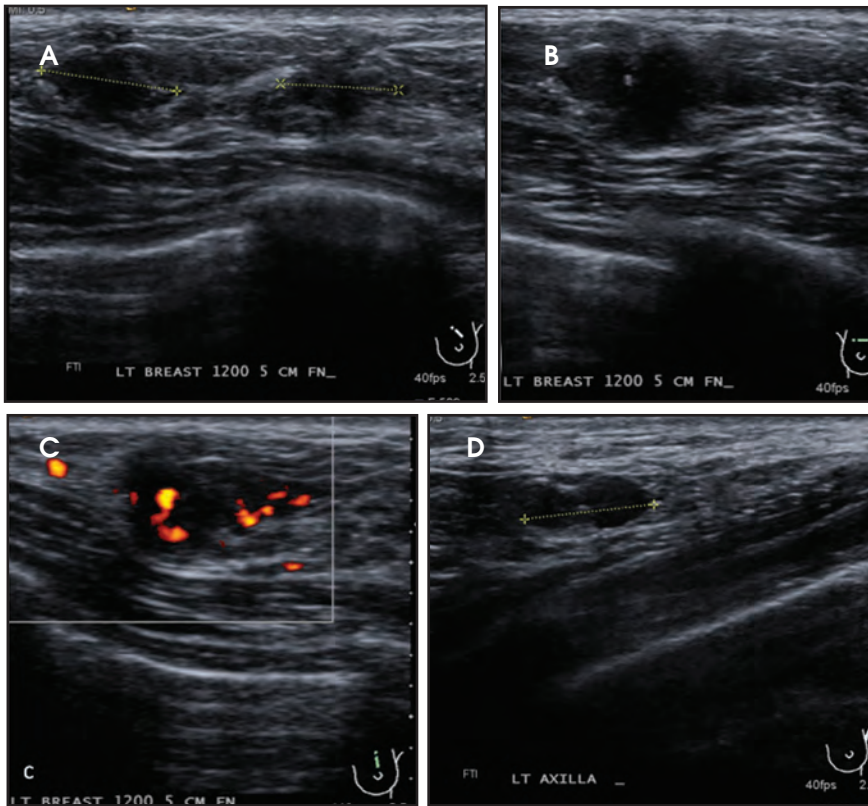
Left breast and left axillary ultrasound. (A) Two contiguous similarly hypoechoic irregular solid masses are noted at 12 o'clock (calipers). Each mass is subcentimeter, measuring 9mm and 8mm. (B) The dominant 9-mm mass corresponds to the highly suspicious mass seen on MRI (Figures 7A - C) and (C) demonstrates significant vascularity. The second similar smaller 8-mm mass corresponds to confluent enhancing foci on MRI. (D) Ultrasound of the left axilla demonstrates the 9-mm lymph node with thickened cortex noted on MRI and is categorized as suspicious. Overall, the BIRADS assessment is confirmed as category 5, highly suspicious for malignancy. Recommendation: Ultrasound-guided core-needle biopsy of both masses and ultrasound-guided fine-needle aspiration of the left axillary lymph node.
